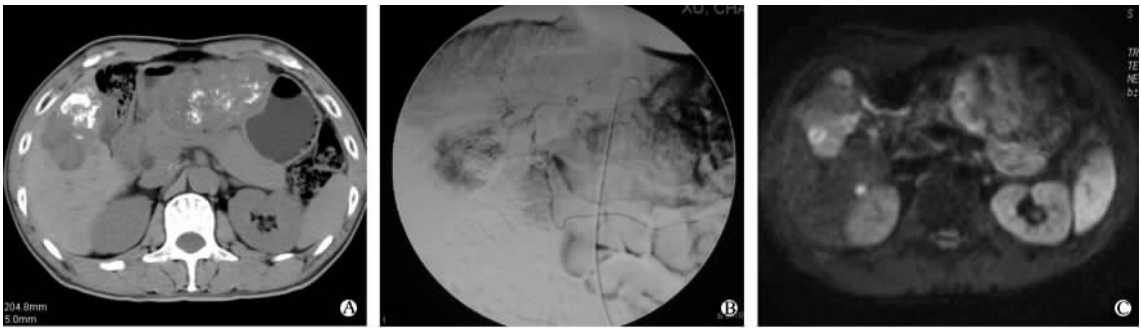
肝癌 TACE 术后碘油沉积不完整病灶的 CT、DSA 和 DWI 图像特征
